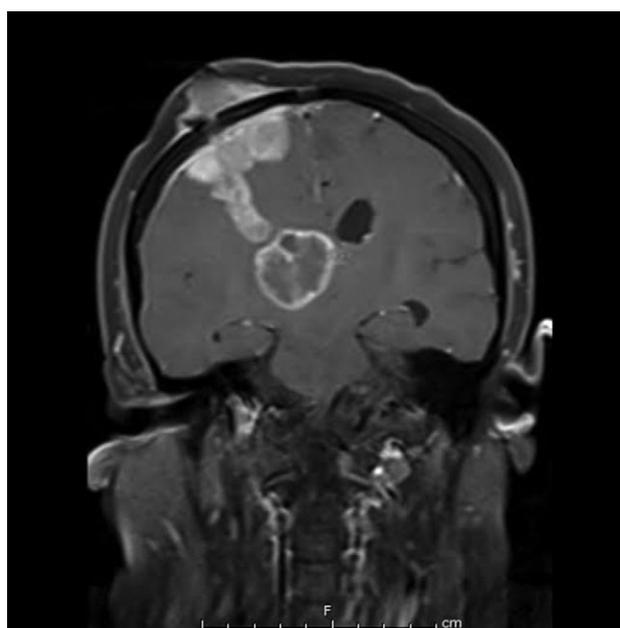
T1-weighted coronal MRI with gadolinium showed seeding of the tumor along the entire stereotactic biopsy trajectory and a new contrast-enhancing lesion in right frontal region with subcutaneous invasion.
